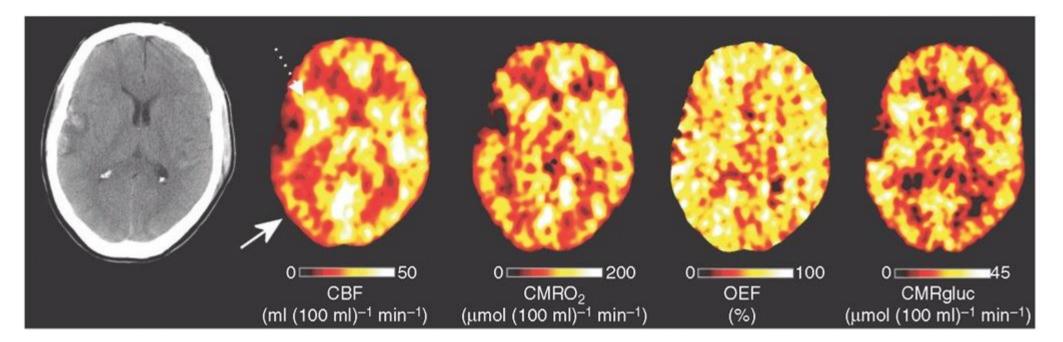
Positron emission tomography (PET) imaging of regional metabolism following head injury. X-ray CT, PET cerebral blood flow (CBF), oxygen metabolism (CMRO2), oxygen extraction fraction (OEF) and glucose metabolism (CMRglu) images obtained following early head injury. Note the right temporal haemorrhagic contusion with surrounding rim of hypodensity on the X-ray CT. The lesion core reflects infarcted brain with no or very low CBF. The pericontusional cerebral hemisphere displays variable pathophysiology. Immediately adjacent to the lesion core (dotted arrow), CBF is increased, CMRO2 and OEF variable but glucose metabolism increased, while the right parietal occipital cortex (white arrow) demonstrates a decrease in CBF and CMRO2 with an increase in OEF and variable glucose metabolism suggestive of regional cerebral ischaemia. The increase in CMRglu implies a switch to non-oxidative metabolism of glucose in order to meet underlying metabolic needs.
